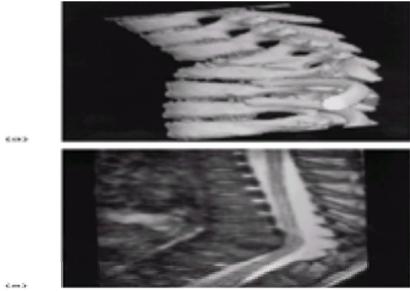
Spondylodiscitis in a 12-year-old boy with dorsal kyphosis and vertebral block. (a) Three-dimensional CT shows the spinal deformity. (b) T_2 -weighted MR image shows the cord compression.
